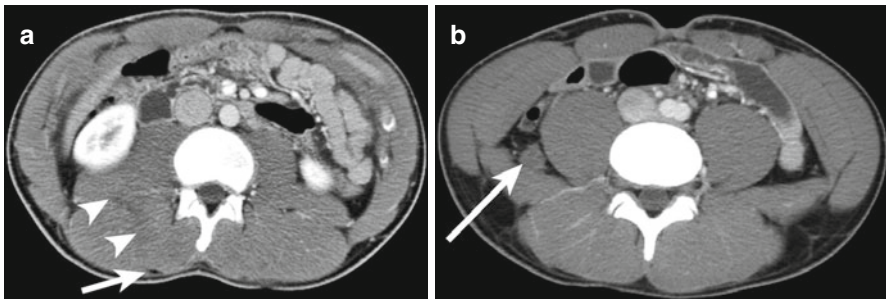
A 20 year-old male sustained a stab wound to the right flank during assault. (a) Contrast-enhanced CT shows the stab wound entry site (*arrow*) and the tract (*arrowheads*) through the posterior musculature. (b) More inferiorly, there is a small hematoma (*arrow*) between the psoas and quadratus lumborum muscles. The retroperitoneal viscera were intact
